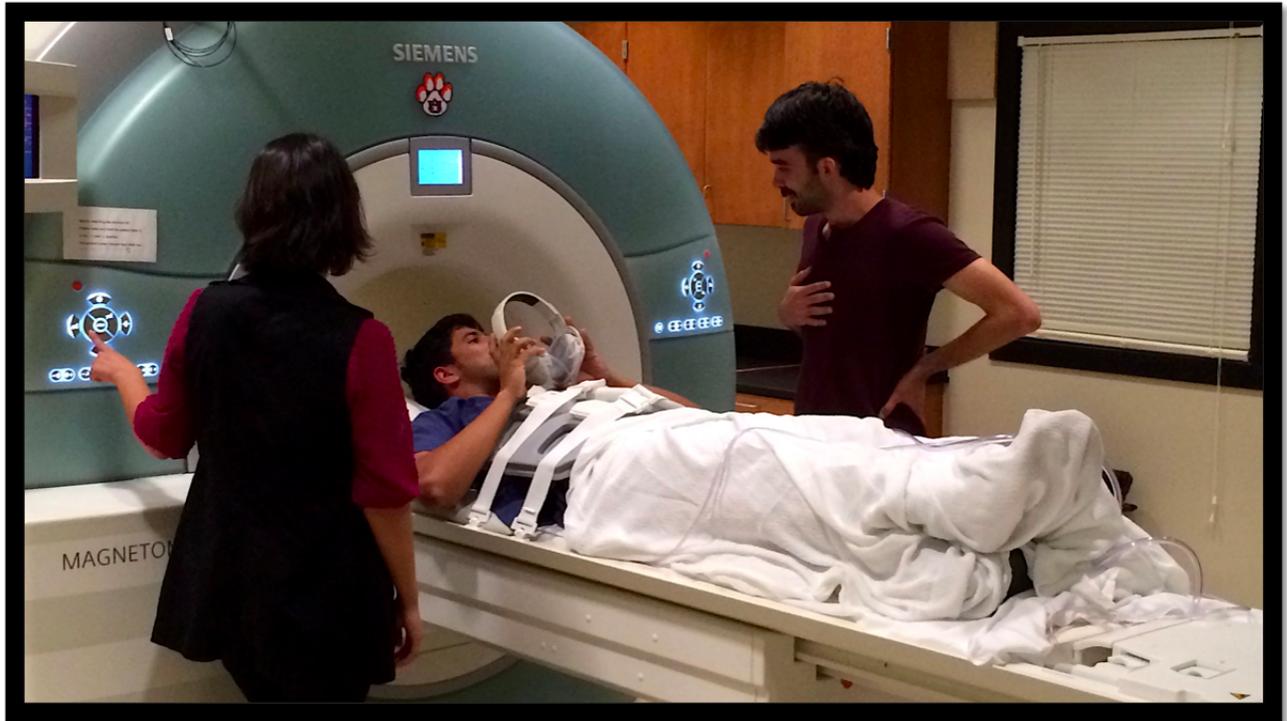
Siemens Verio Open-Bore 3T MRI Scanner
